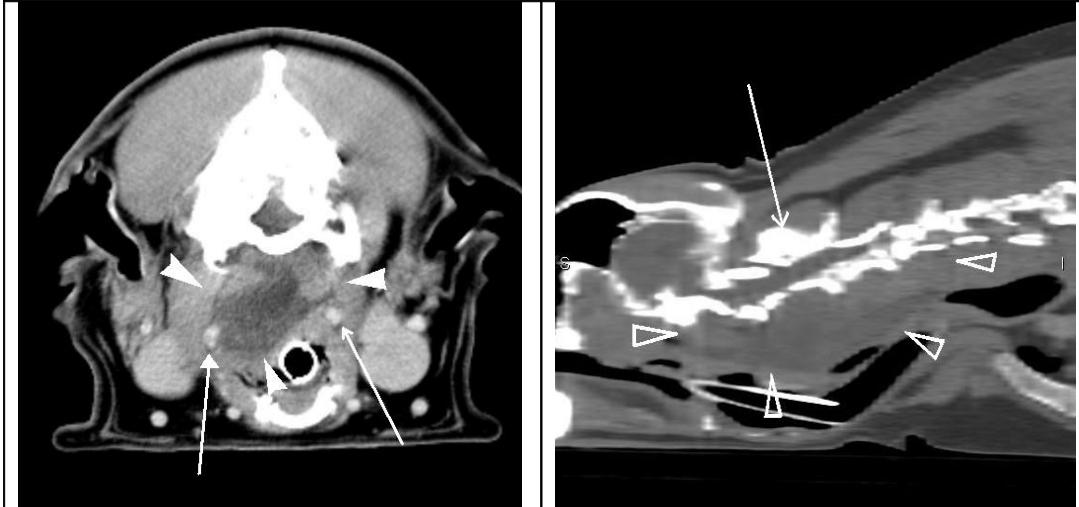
axial CT image through the head just caudal to the tympanic bullae. Mass is marked with arrowheads with the internal carotid arteries marked with the long arrows
